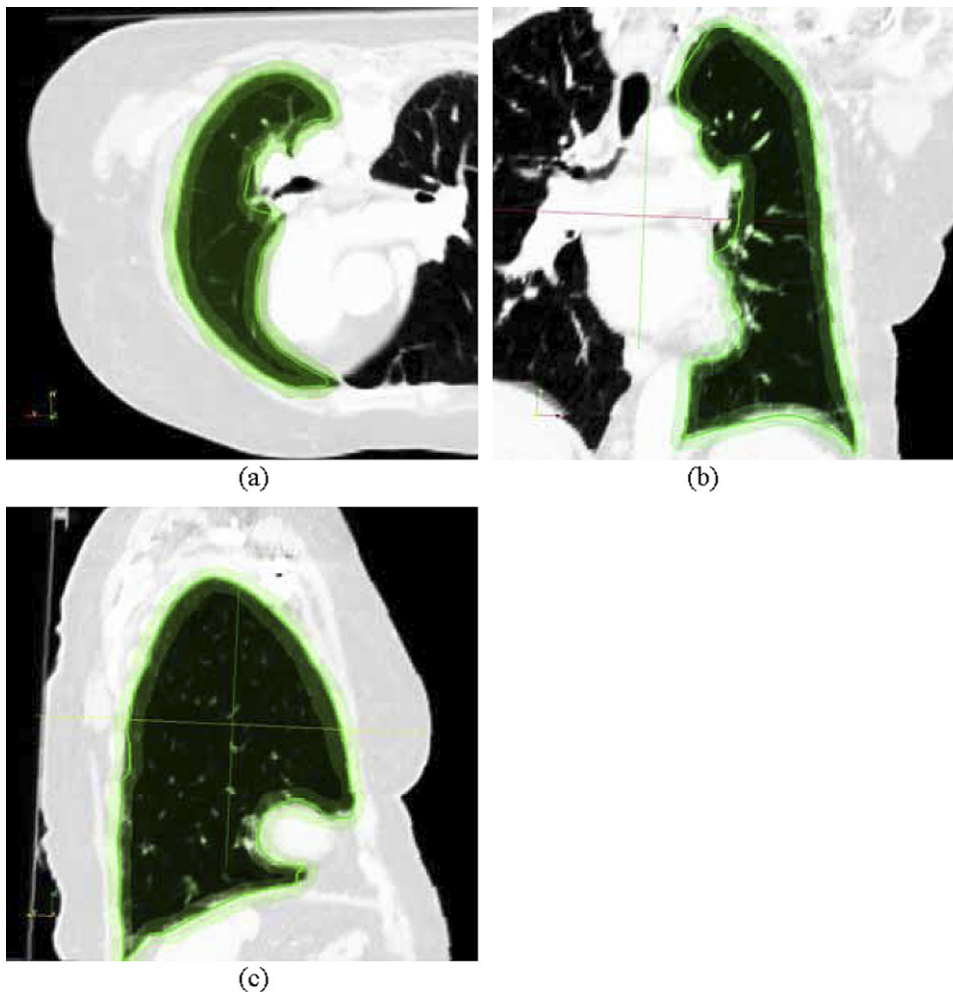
Computed tomographic images with manual contours and the narrow bands for patient 1. The narrow bands are shown in light green and the contours are green curves. (a) Transverse view; (b) coronal view; (c) sagittal view.
